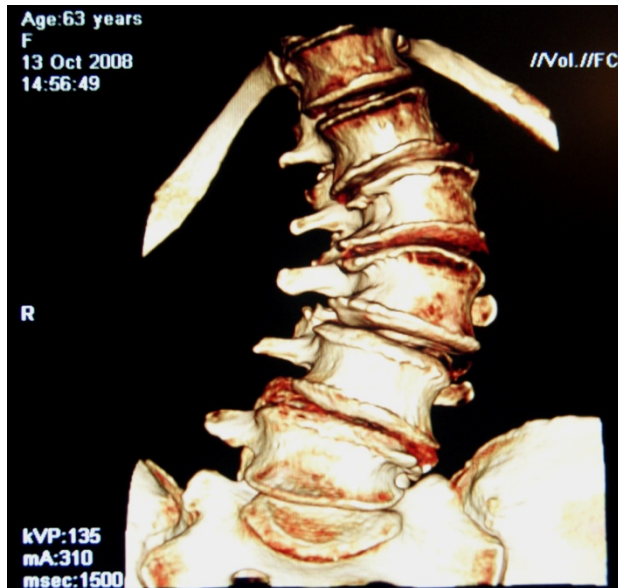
is an AP 3D CT image. This better helps us appreciate the degenerative changes in 3 dimensions. Lateral listhesis may be seen at multiple levels.
